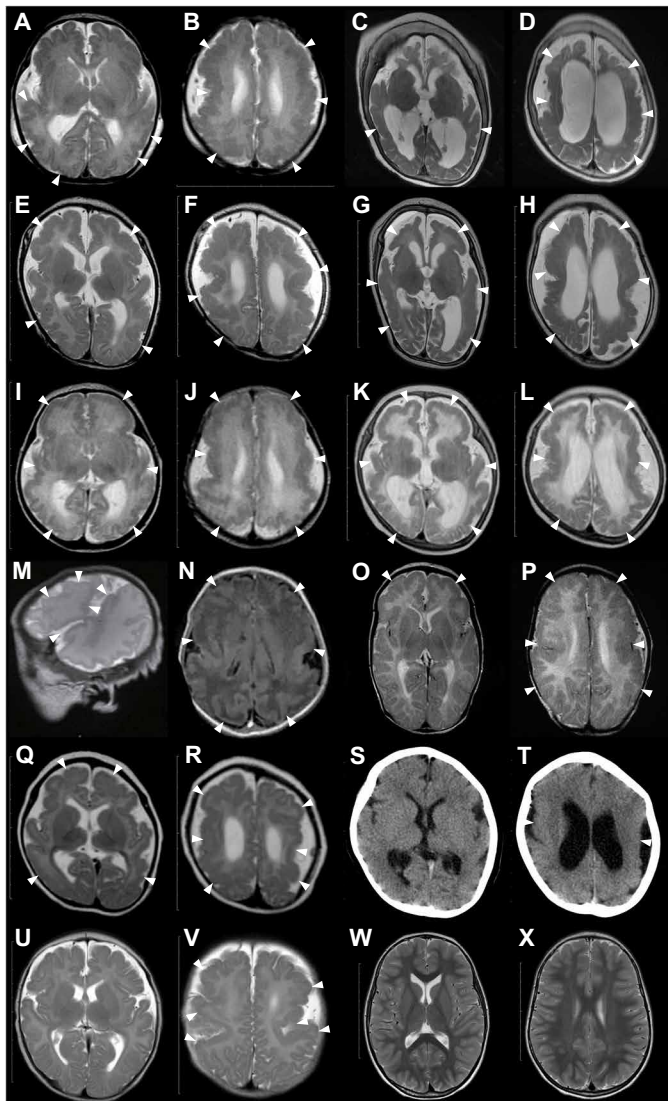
Bilateral perisylvian polymicrogyria associated with de novo *ATP1A3* mutations. Brain MRI scans of patient 1 [(A) and (B) at 1 day old, (C) and (D) at 2 years and 10 months], patient 3 [(E) and (F) at 2 months old, (G) and (H) at 8 months], patient 4 [(I) and (J) at 3 days old, (K) and (L) at 4 months], patient 5 [(M) and (N) at 2 days old], patient 6 [(O) and (P) at 2 months old], patient 7 [(Q) and (R) at 5 months old, (S) and (T) at 3 years old], patient 8 [(U) and (V) at 2 months old], and a neurologically normal control [(W) and (X) at 3 years old]. All images are T2-weighted axial brain MRI, except for a T2-weighted sagittal MRI (M), a fluid-attenuated inversion recovery axial MRI (N), and an axial cranial CT (S and T). Brain MRI showed irregular small gyri with apparent cortical thickening, compatible with polymicrogyria, over the perisylvian cortex (arrowheads). Patients 1, 3, and 4 (A to L) showed progressive atrophic changes with dilation of the subarachnoid space and lateral ventricles.
